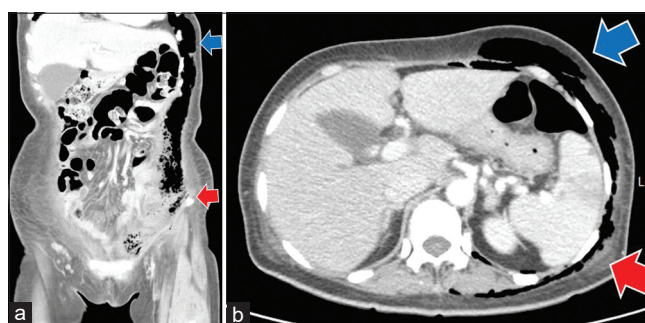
(a and b) Computed tomography of the chest and abdomen showed subcutaneous emphysema (blue arrow) and abscess formation (red arrow) in the left chest wall extending to the left abdominal wall
